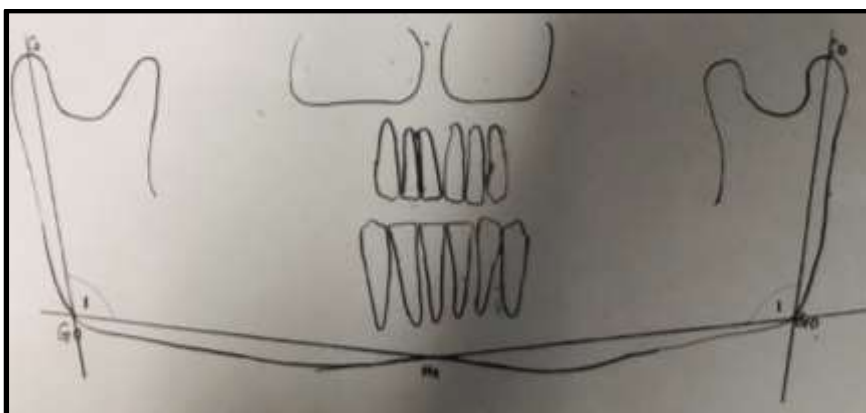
Orthopantomogram showing Gonial angle on both the sides. Landmarks depicted: Co-Condylion, Go-Gonion, Me-Menton 1. Gonial angle
